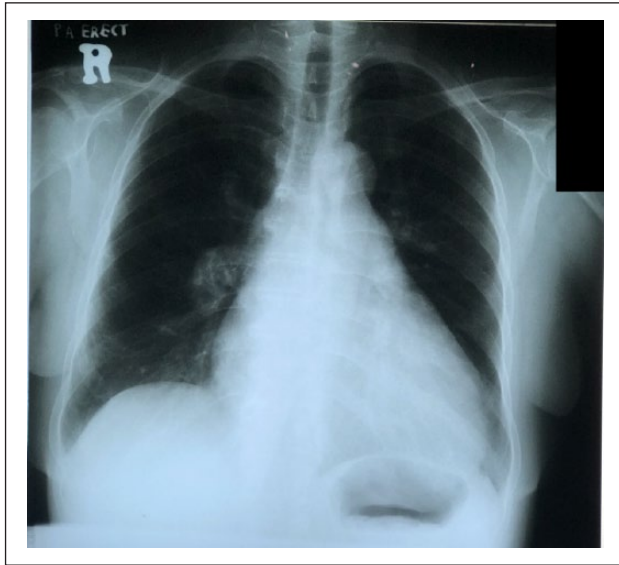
First chest radiograph upon presentation to the Emergency Department. This chest radiograph showed the presence of air under the right hemi-diaphragm and also slight right lower zone infiltrates.
